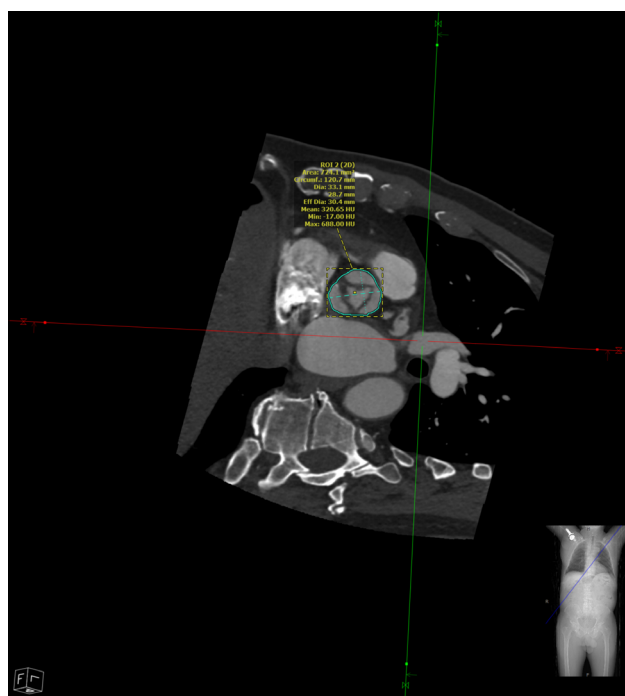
Cardiac computed tomography angiogram cross-sectional image demonstrating focal minimal calcification of the aortic valve (circled).
